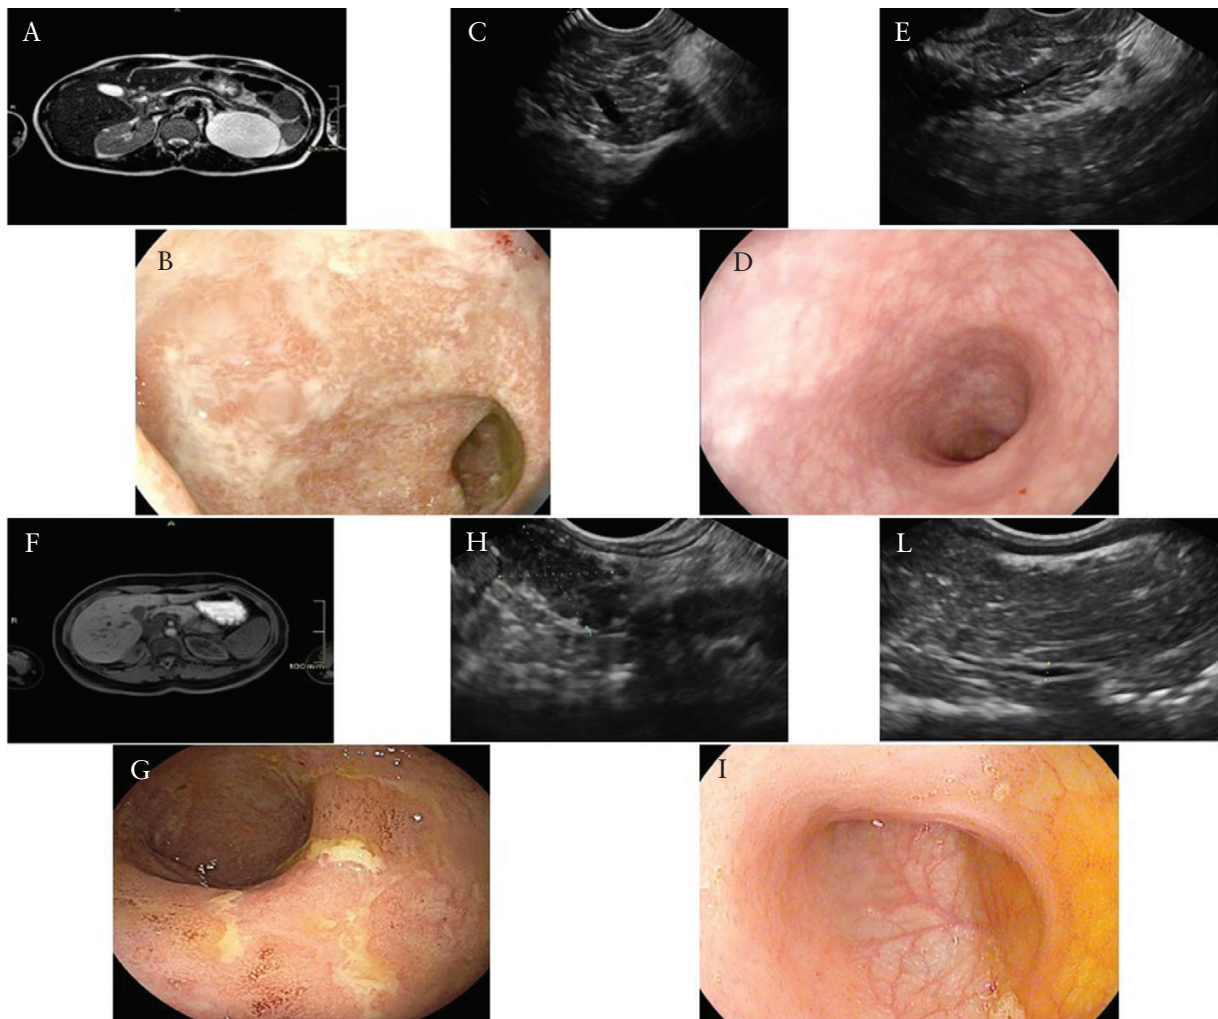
Magnetic resonance imaging, endoscopic and endoscopic ultrasound findings before and after ustekinumab therapy in a patient with type II autoimmune pancreatitis and ulcerative colitis [Panel A–E] and in a patient with type II autoimmune pancreatitis and Crohn's disease [Panel F–J] [A] Axial T2 weighted image demonstrating a slightly dilated Wirsung duct. [B] Multiple erosions and ulcers located in sigma, with loss of mucosal vascular pattern and friability. [C] Hypotrophic pancreas, with inhomogeneous hyperechoic echostructure and multiple hyperechoic spots and strands. At the isthmus dilated Wirsung [4 mm], with hyperechoic walls. [D] Endoscopic remission 6 months later, having started therapy with ustekinumab. [E] Stable chronic pancreatitis 6 months later, having started therapy with ustekinumab. [F] Axial T1 weighted image with fat suppression showing hypointense signal of the pancreatic tail when compared with the normal pancreatic parenchyma, corresponding to hyperintense signal in both T2 and, above all, diffusion weighted images, strongly suggesting autoimmune aetiology. [G] Aphthous lesions in the ileum. [H] Enlarged and swollen pancreas, with inhomogeneous echostructure with hyperechoic spot and strands. Pancreatic tail appears more hypoechoic and swollen compared with the rest of the organ, regular Wirsung. [I] Endoscopic remission 6 months later, having started therapy with ustekinumab. [J] No more swollen or oedematous parenchyma, with only few hyperechoic spots without strands 6 months later, having started therapy with ustekinumab.
